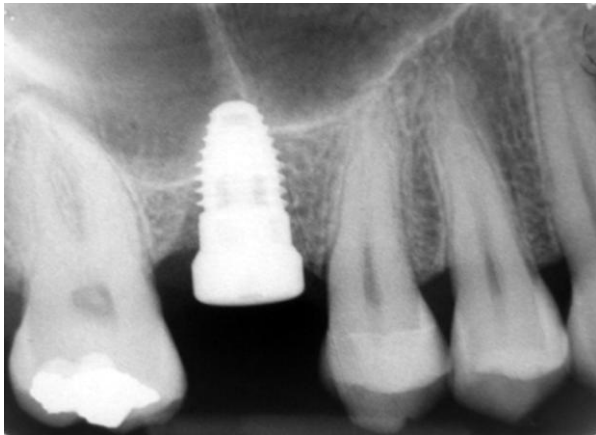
Radiograph showing implant placed at site # 16. Apical portion of the implant is seen penetrating the sinus floor. (3 months post-operative)
